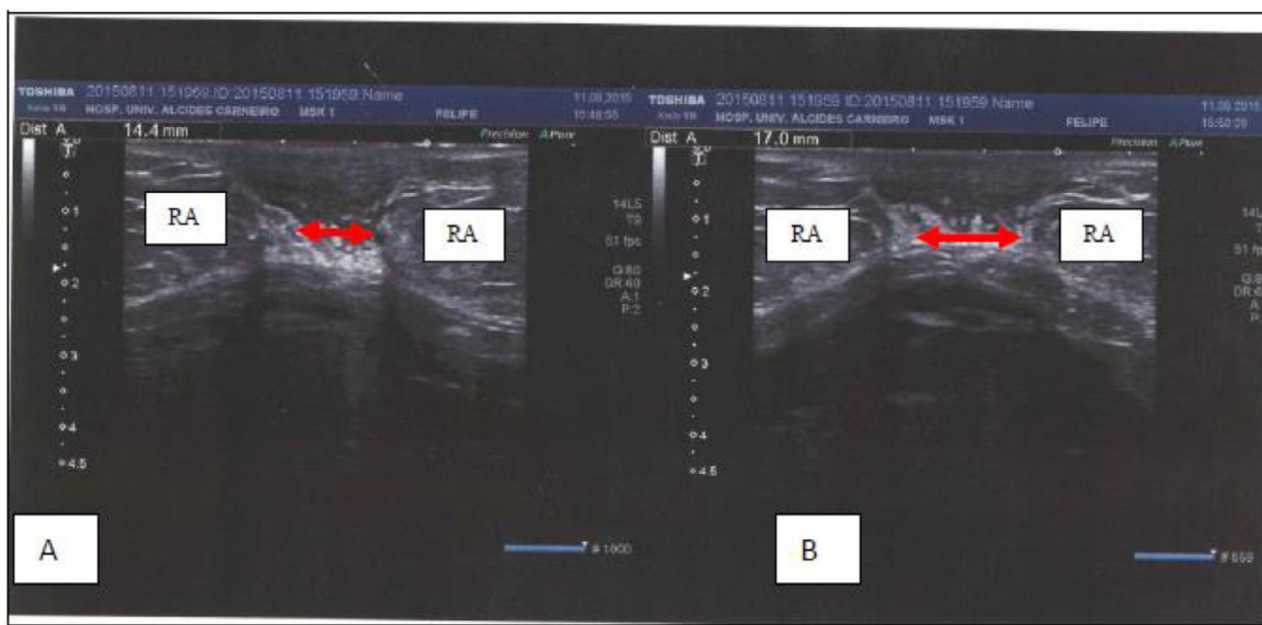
Abdominal USG image of supraumbilical region of study participant, in dorsal decubitus position, with flexed hips and knees and feet resting on the bed. (A) The DIR of 1.44 cm at rest. (B) The DIR of 1.7 cm during expiration and contraction. Measurements of DIR obtained in abdominal contraction were taken. IRD, interrecti distance; RA, rectus abdominis; USG, ultrasonography.
